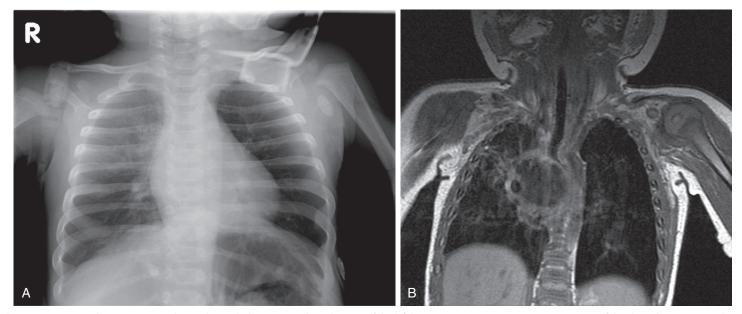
Bronchogenic cyst. A, Chest radiograph demonstrates hyperlucency of the left lung. B, Magnetic resonance imaging (MRI) of the chest demonstrates a large, centrally located cystic lesion of the left hilum with compression of the adjacent airway. (Courtesy Beverly Newman, MD, Pittsburgh, Pa.)
